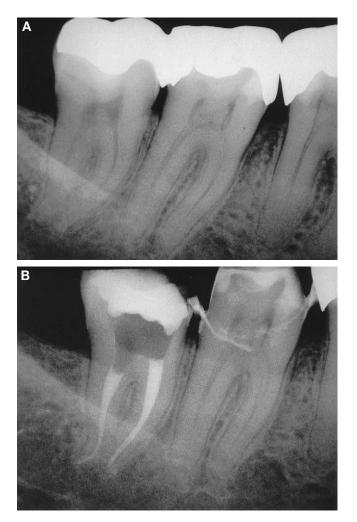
Tooth No. 32. (A) Preoperative radiograph. (B) Postoperative radiograph.
